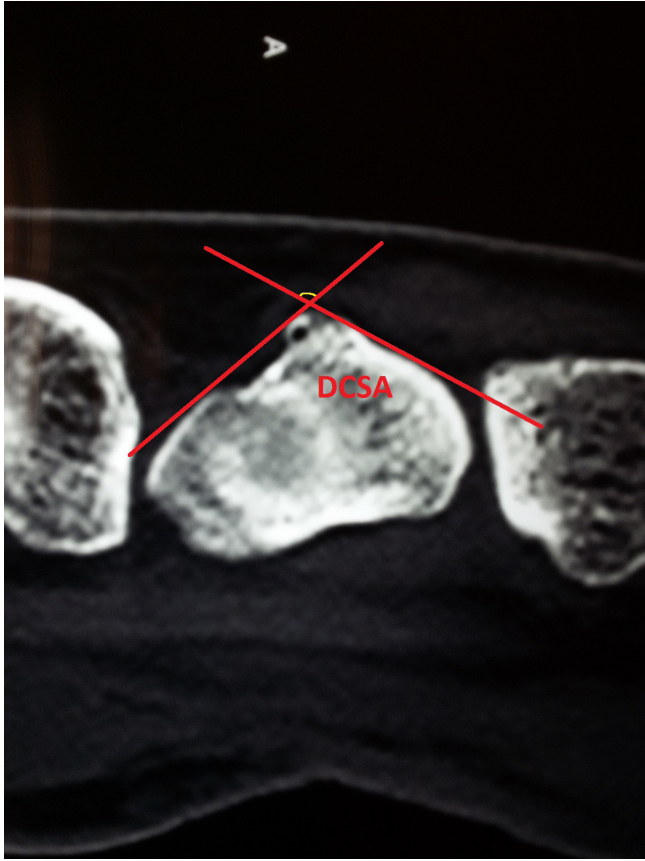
Measurement of the dorsal cortical angle (DSCA) on CT scan.
